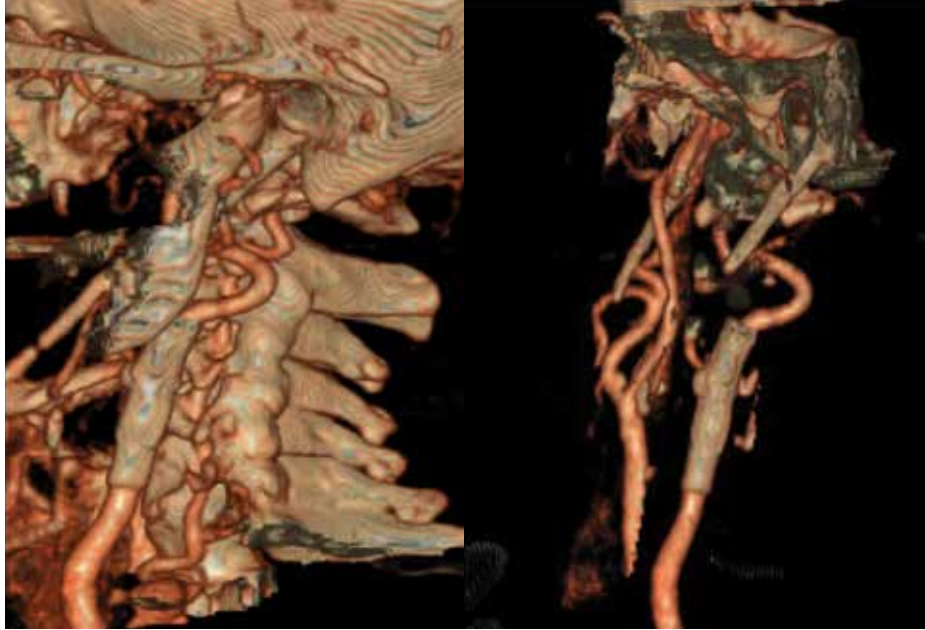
After 6 months, stent patency was still present according to the control CT angiogram.
